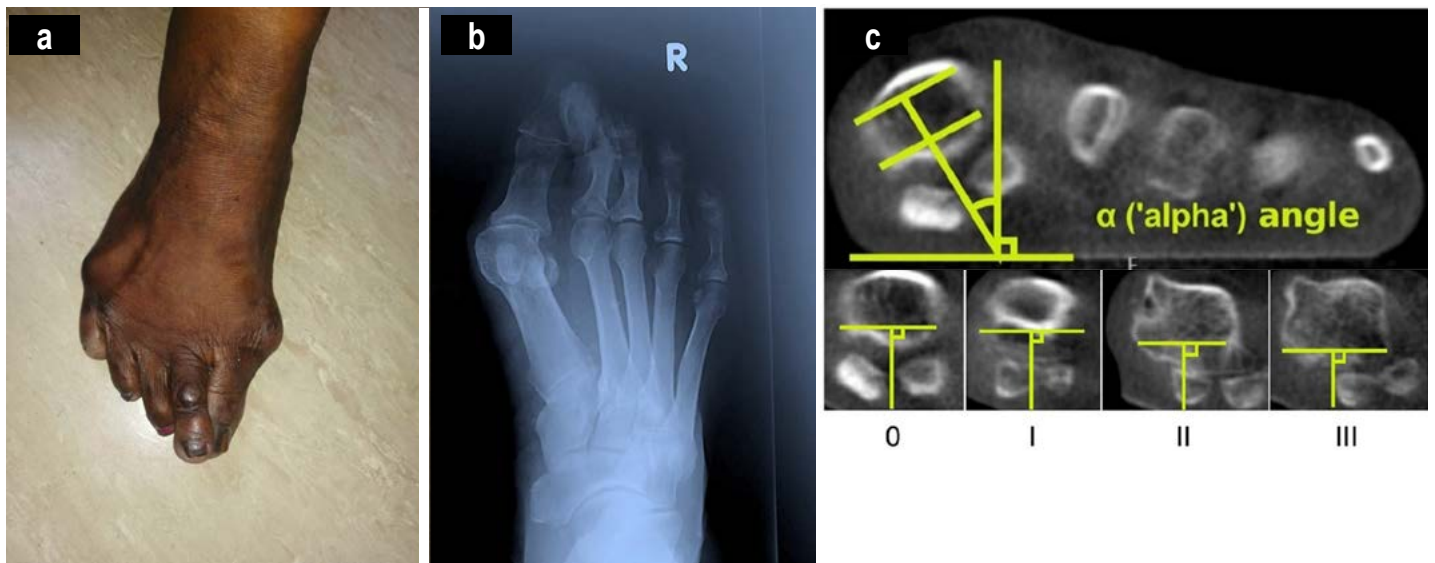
Images depicting the right foot of a 72-year-old female with severe hallux valgus with crossover toe (a). Weight-bearing view X-rays confirm severe hallux valgus with crossover toe (b). Calculation of the  $\alpha$  angle in the axial image of weight-bearing computed tomography (WBCT); measurement of tibial sesamoid subluxation (TSS) grades in the axial image of weight-bearing computed tomography (WBCT) (c).
